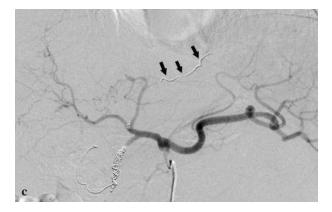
Selective injection of contrast medium with the tip of the catheter located into the left hepatic artery (black arrow) depicts reflux into the right hepatic artery and clear opacification of the end branches of the left hepatic artery. One end branch (white arrows) projecting just below the left diaphragm seems to be a non-hepatic artery. (b) Cone beam CT after injection of contrast medium through the microcatheter in the left hepatic artery clearly shows the extrahepatic artery (white arrows) located at the level of the left diaphragm : the left inferior phrenic artery. (c) After proximal coil-embolization (black arrows), there was no more opacification of this non-hepatic artery.
